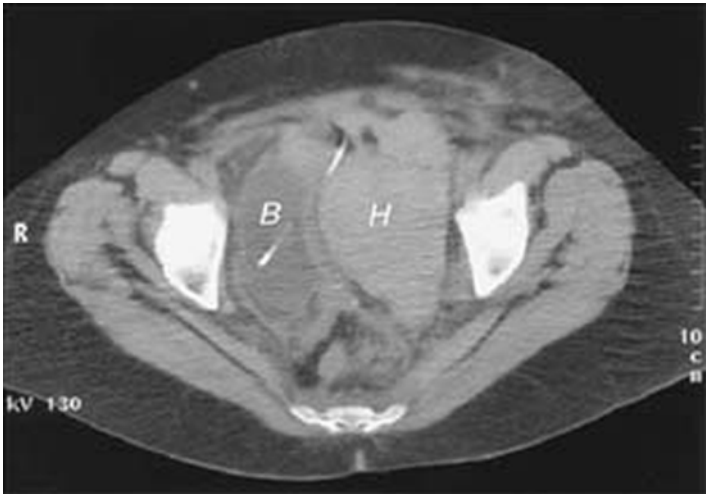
Pelvic computed tomography scan of patient with a 10-cm hematoma (*H*) in the space of Retzius next to the bladder (*B*) (Walters et al. [24], with permission of the American College of Obstetricians and Gynecologists)
